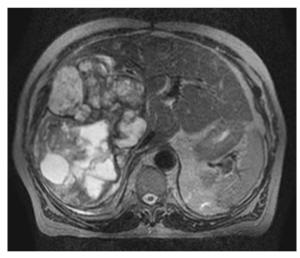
Axial T2 weighted MRI with contrast showing metastatic GIST to liver
